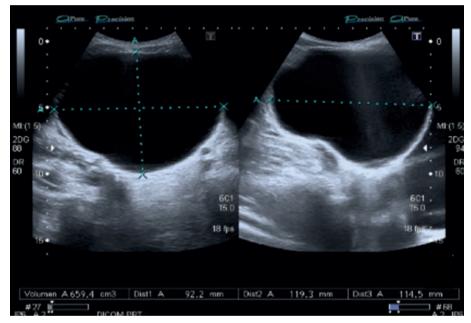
Ultrasound examination: large (92.2 × 119.3 × 114.5 mm) cystic lesion seemingly attached to the right adnexa.
